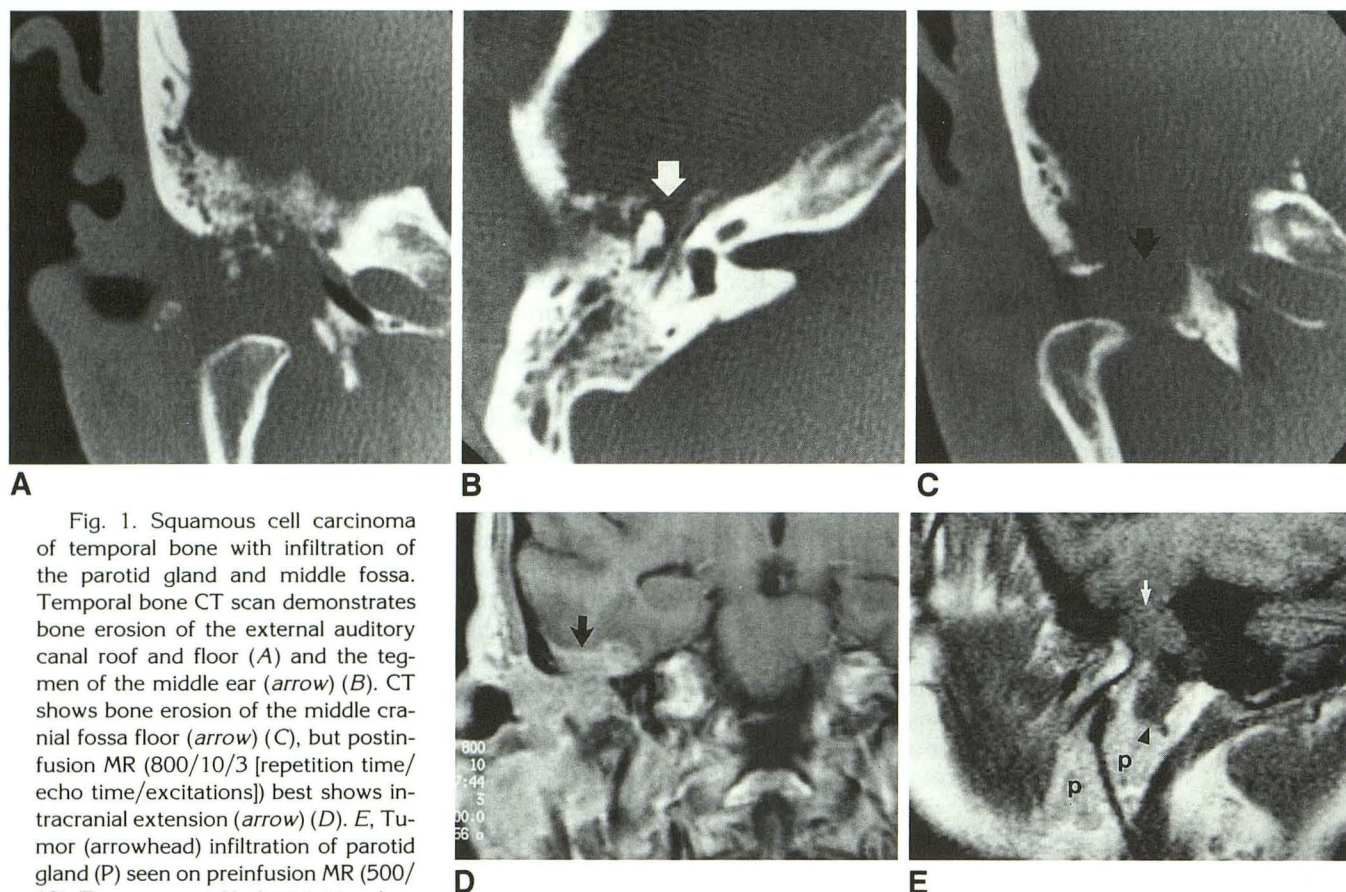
Squamous cell carcinoma of temporal bone with infiltration of the parotid gland and middle fossa. Temporal bone CT scan demonstrates bone erosion of the external auditory canal roof and floor (A) and the tegmen of the middle ear (arrow) (B). CT shows bone erosion of the middle cranial fossa floor (arrow) (C), but postinfusion MR (800/10/3 [repetition time/echo time/excitations]) best shows intracranial extension (arrow) (D). E, Tumor (arrowhead) infiltration of parotid gland (P) seen on preinfusion MR (500/10). Temporomandibular joint involvement is best seen on sagittal MR (E) but is also seen on CT (A and C). The arrow indicates the eroded floor of the middle cranial fossa.
